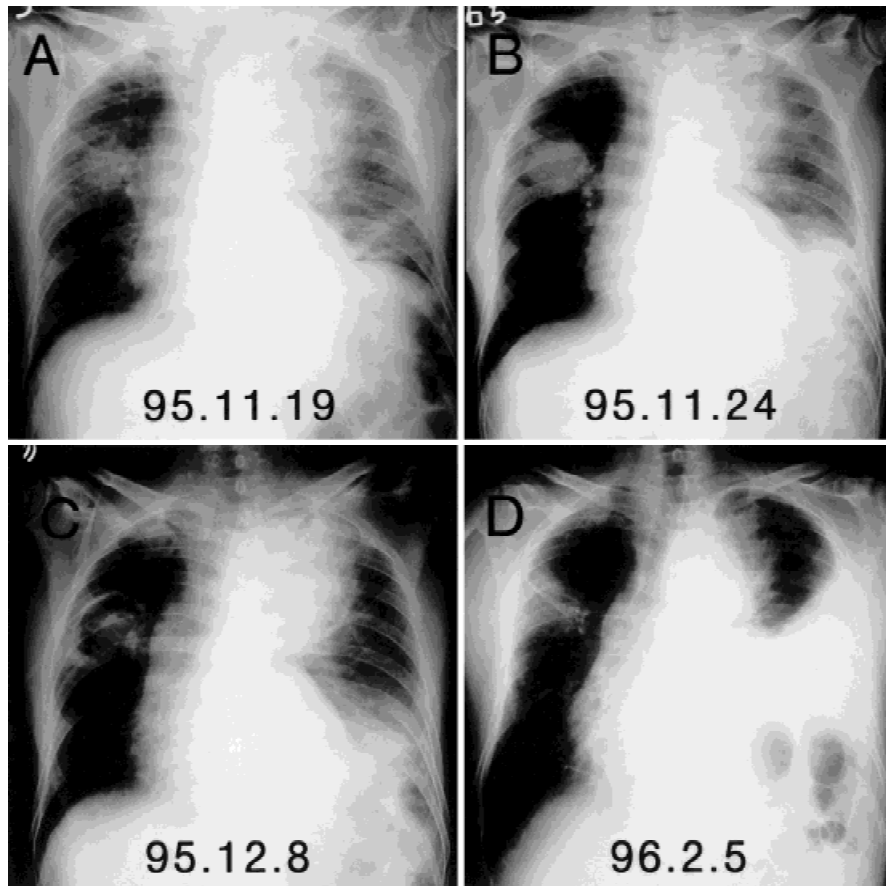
Chest X-ray film showing consolidation shadow adjacent to the aortic arch in the left upper lobe and a round lesion in the right upper lobe (A and B). A "fungal ball"-like shadow is in the right upper lobe (C). Pleural effusion is in the left lung (D).
